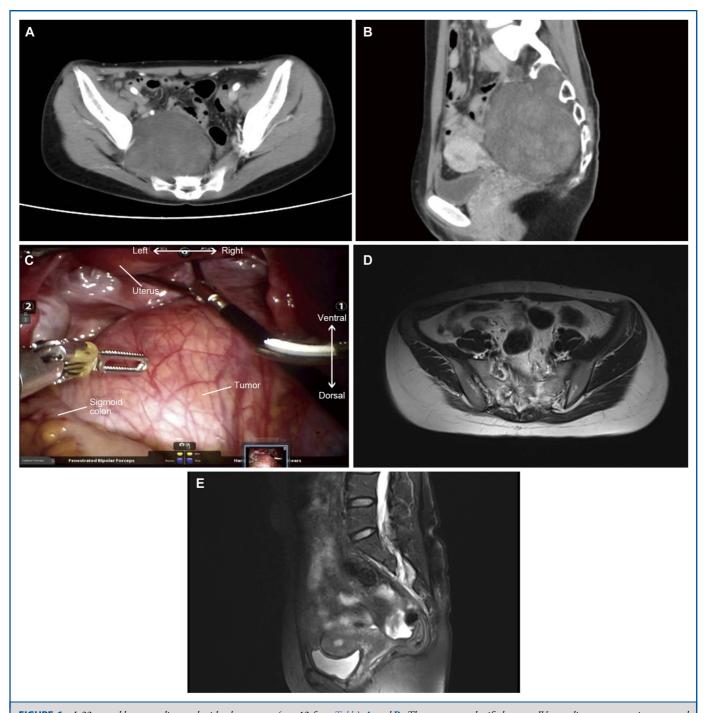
A 22-year-old woman diagnosed with schwannoma (case 12 from Table). A and B, The tumor was classified as type IV according to preoperative computed tomography. C, Robotic system was used to dissect surrounding vessels and other vital tissues. D and E, No local recurrence was observed during a 22.8-month follow-up.
